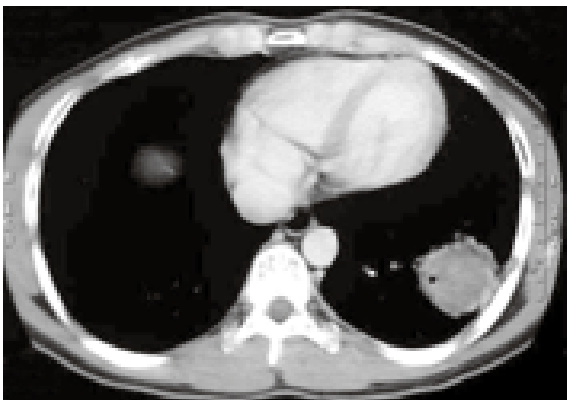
Enhanced axial CT image of the thorax taken at the level of lower lung lobes.
